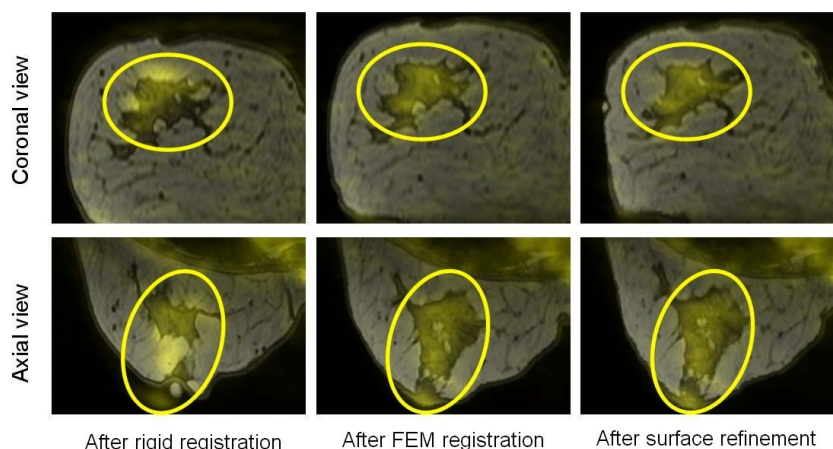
Registered and fused PET and MRI breast images. Yellow: PET. Gray: MRI. The suspicious lesion area is circled.
